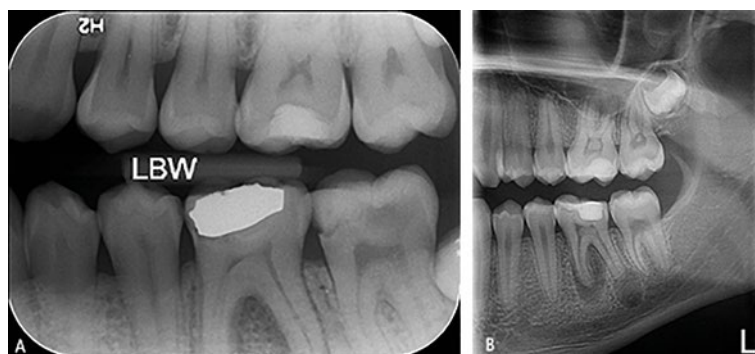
a) Example of an intraoral bitewing. b) Example of an extraoral bitewing on OP300 panoramic machine
